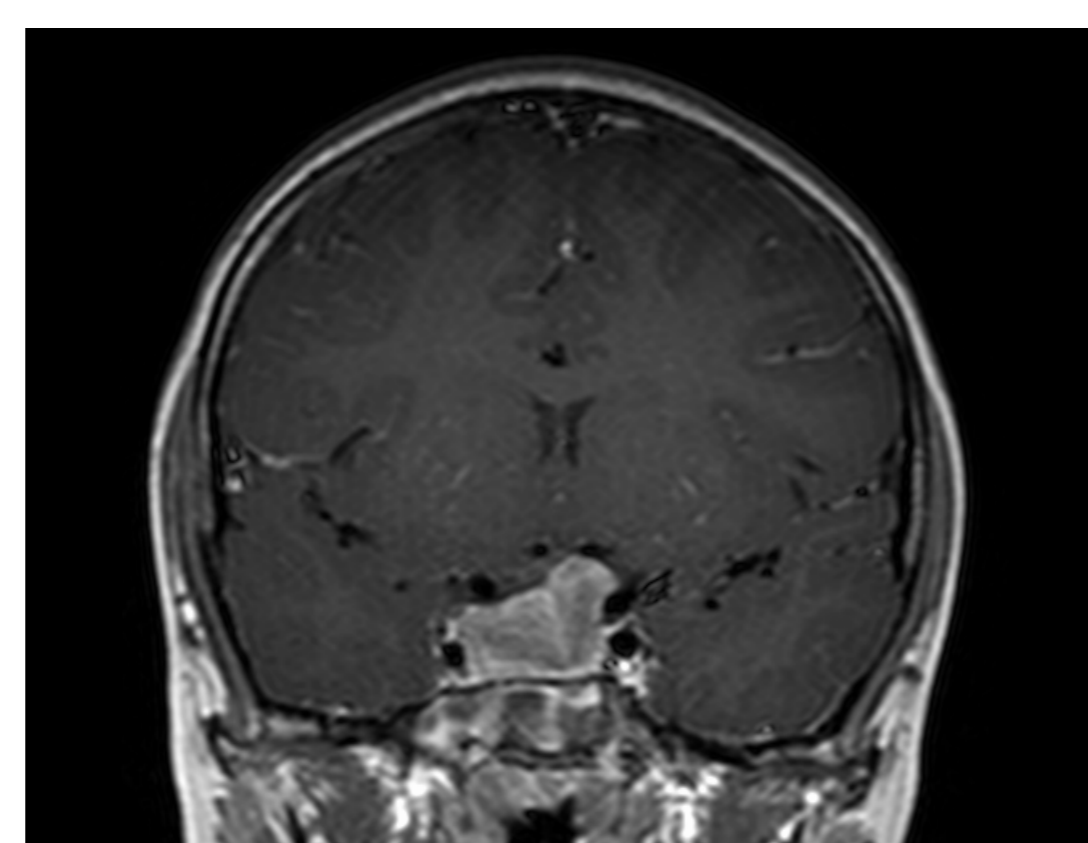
MRI, T1, 3 months after first surgery
